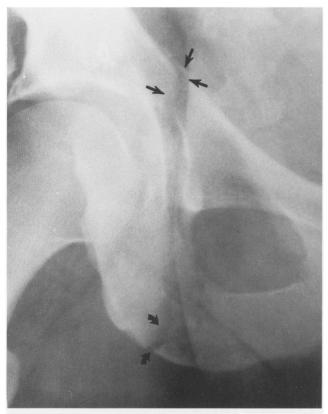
Radiographs and CT's of a T-shaped acetabular fracture.
